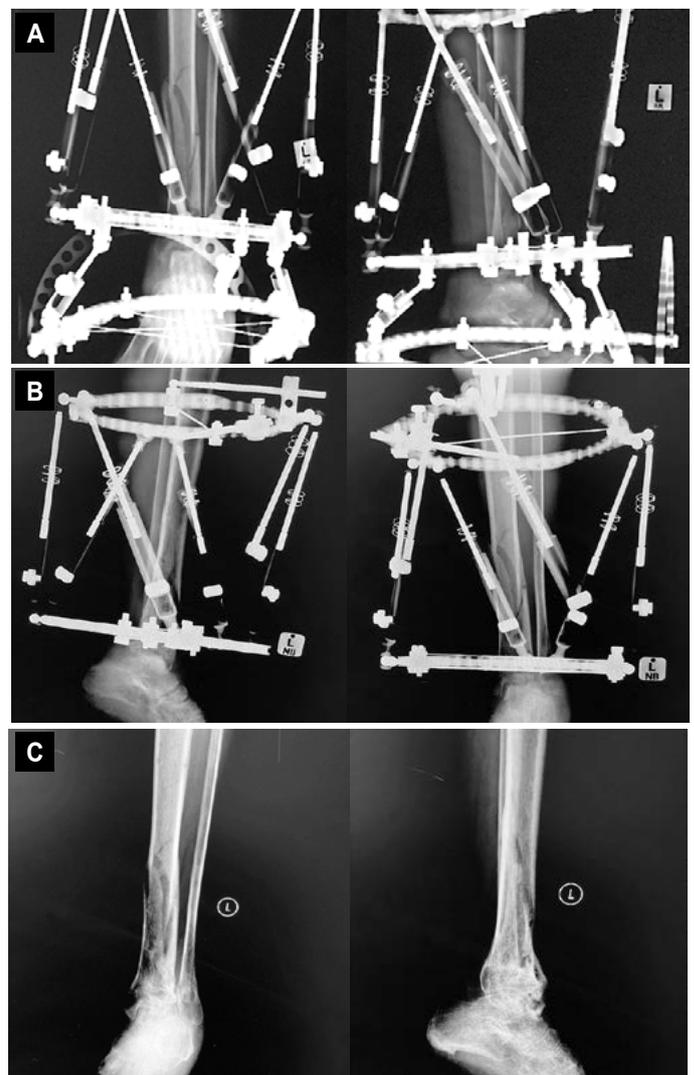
A) Anteroposterior and lateral X-ray with good initial tibial alignment, and ankle joint in neutral, with proximal and distal tibial ring, and foot plate in situ. B) Foot plate removed at six weeks, with evidence of early ankle arthritis and equinus contracture. C) Radiographic fracture union, post-traumatic arthritis and equinus deformity after frame removal
